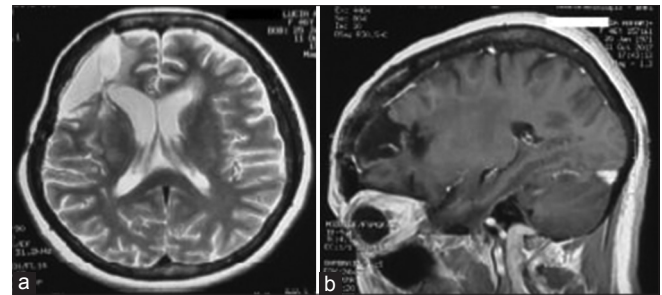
(a) Axial and (b) sagittal magnetic resonance imaging (MRI) scan demonstrating the absence of primary site tumor recurrence and the evidence of previous surgical resection.
